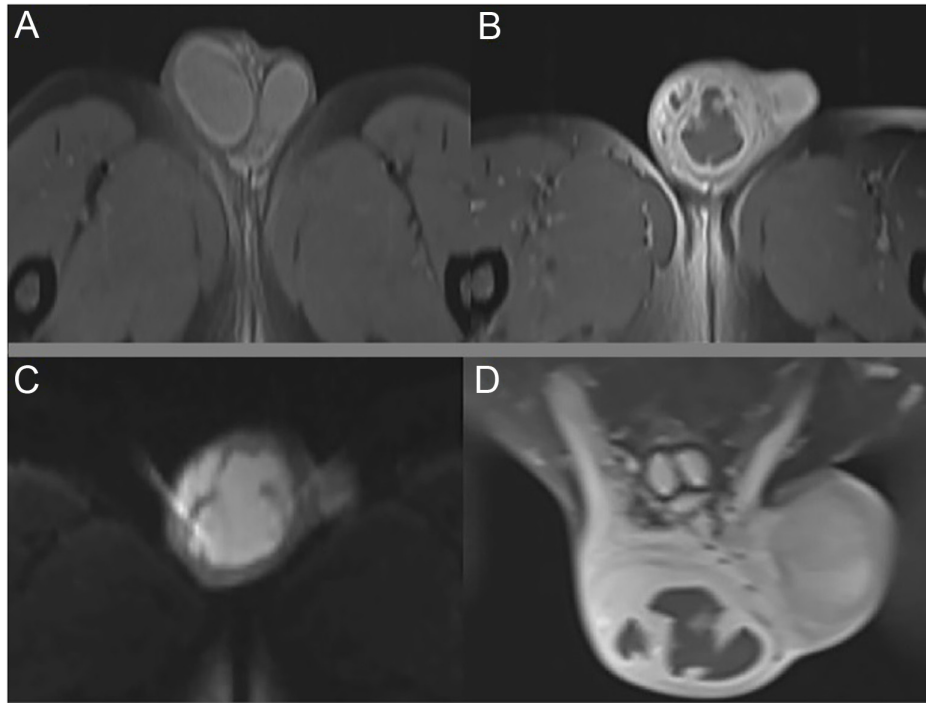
(A-D) Nonenhanced T1 weighted axial plane (A), fat-suppressed enhanced T1 weighted axial plane (B), diffusion-weighted axial plane (C), and fat-suppressed enhanced T1 weighted coronal plane (D) magnetic resonance images of the bilateral testis. Heterogeneous signals in nonenhanced T1 weighted image, diffusion restriction, and contrast enhancement were observed in the right testis, while the left testis parenchyma was normal.
